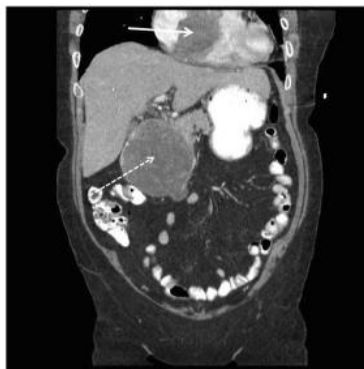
Abdominal CT demonstrating a large, heterogeneous soft tissue mass of the pancreatic head (dashed arrow) and a large, hypodense cardiac mass (solid arrow).
